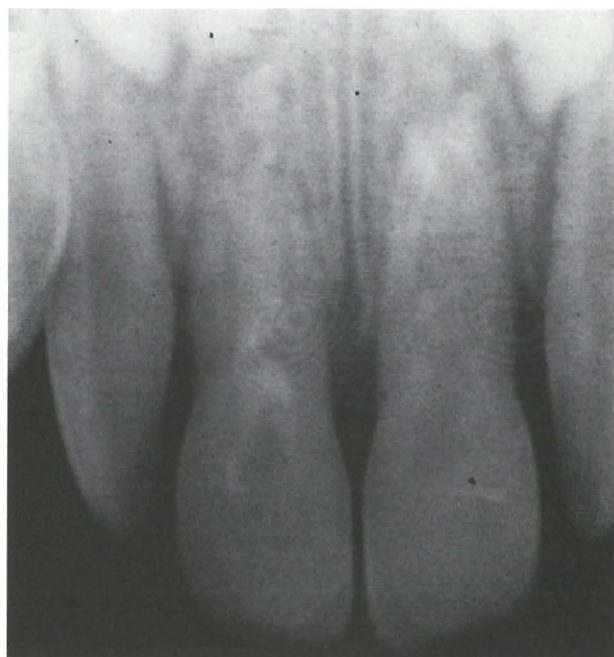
Radiograph of teeth 51 and 61 three months after retrograde spiral root filling with calcium hydroxide (intraoral film). Partial resorption of the filling material.
